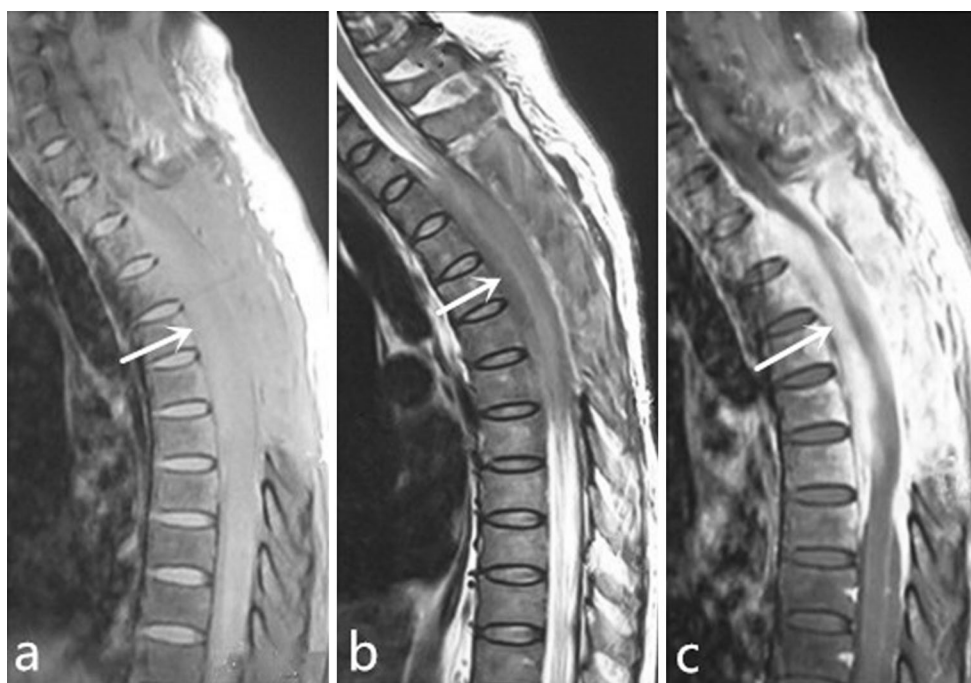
Follow-up MR imaging at clinical relapse (1 month). Meningeal lesions have increased again
